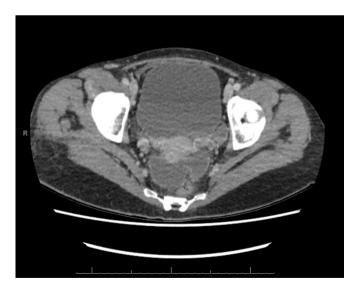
Transverse plane image of CT scan pelvis: An image showing presence of an organising rectouterine collection with free fluid in the pelvic cavity.
